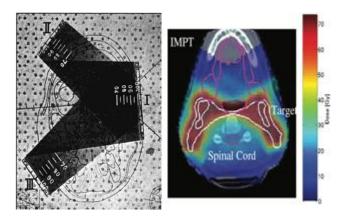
100 years of development in radiation therapy have made a difference. Comparison of an X-ray treatment plan from the early 1900s (a) and a proton treatment plan from the early 2000s ((b), courtesy of AW Chan and AV Trofimov, MGH Boston).
